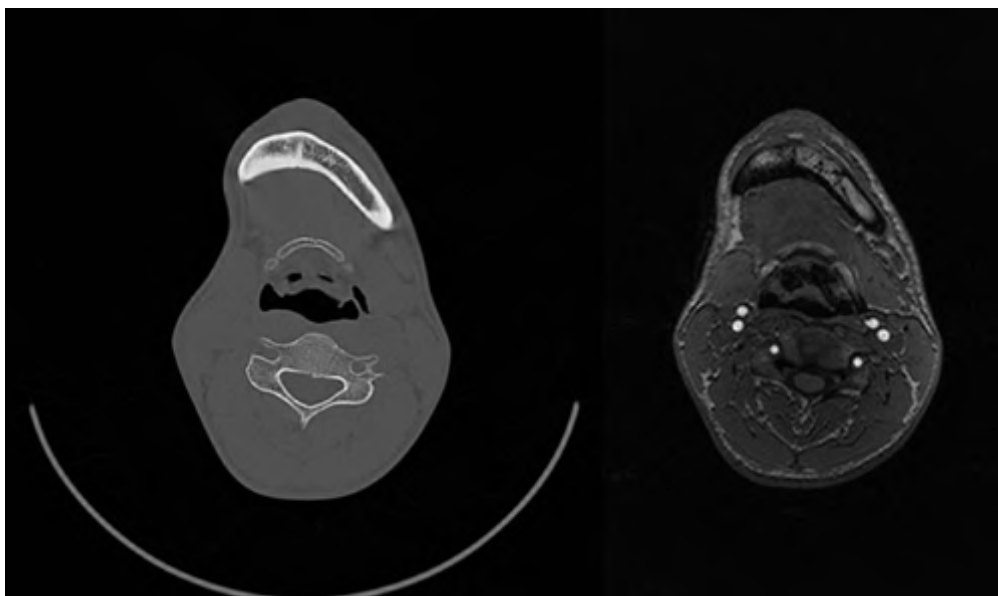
Image of the mandible from the same subject: CT (left), T1-Weighted MRI (right).
